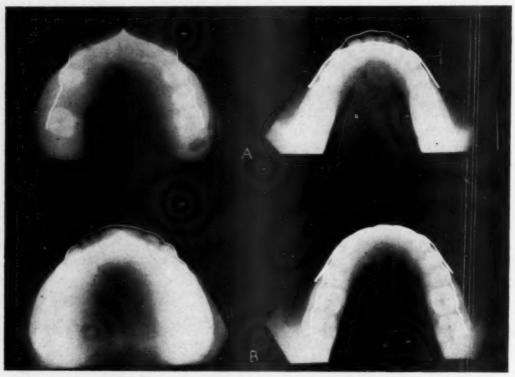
Figure representing x-rays of plaster models taken according to technique of Dr. William B. Downs.
